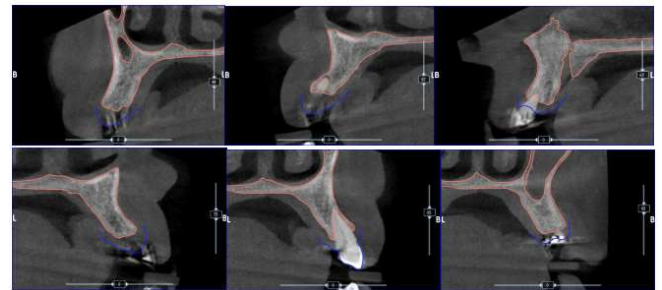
CBCT demonstrating favorable conditions for extractions and immediate implant placement.
